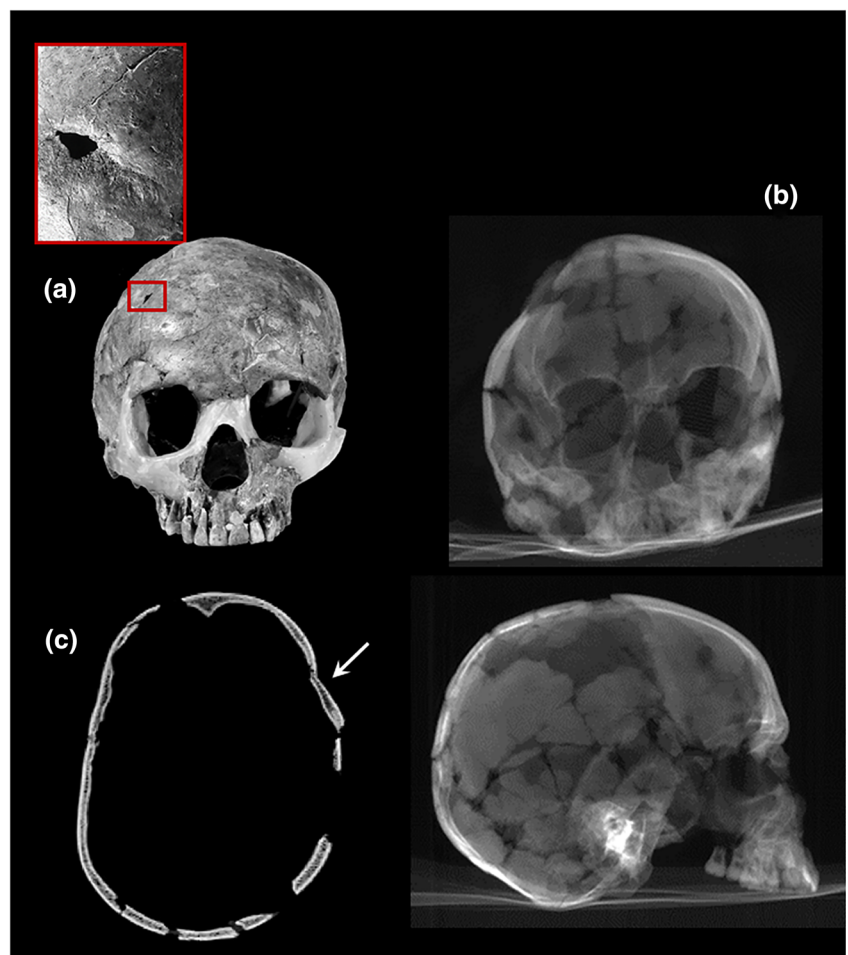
Skull of Qafzeh 11 (Middle Palaeolithic, Israel). (a) Morphological aspect with a focus on cranial lesion (right part of frontal bone). (b) Plain X-ray, frontal and right lateral views. Owing to the fragmentation and superimposition, the fracture line is not visible. (c) Computed tomography (CT) scan axial slice at the lesion level (arrow). A displacement of a fragment of frontal bone is visible, but the fragmentation of the skull and the restoration after its discovery do not formally rule out a taphonomic cause to this aspect [Colour figure can be viewed at wileyonlinelibrary.com]
